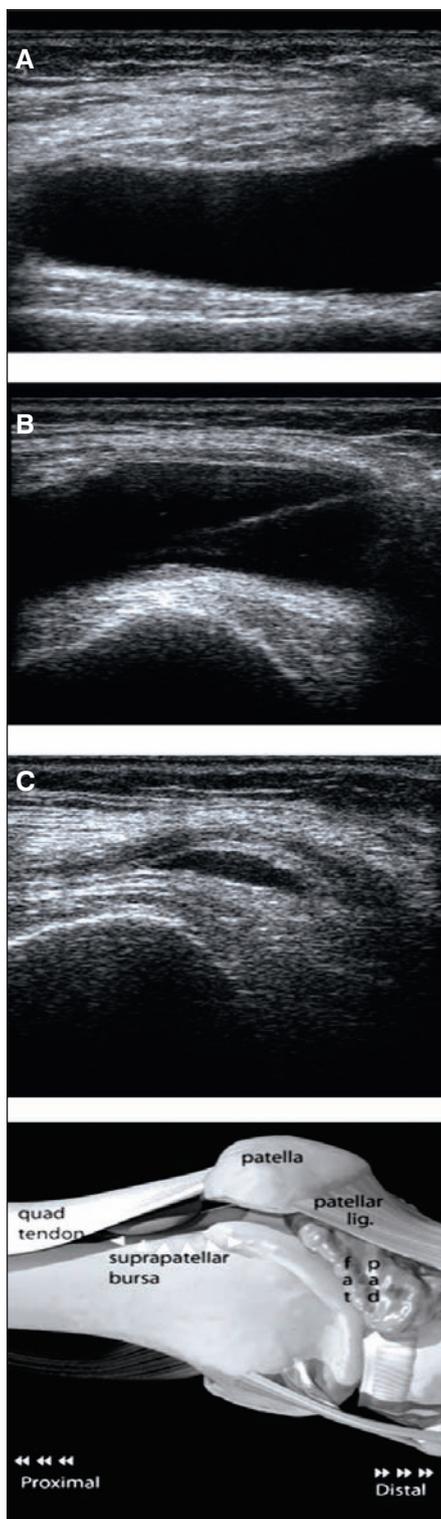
Suprapatellar aspiration.* A. longitudinal views of the suprapatellar pouch/bursa demonstrate a large anechoic fluid collection; B. needle insertion for aspiration; C. post aspiration view. Ultrasound image prior to aspiration allowed determination of no internal debris in the often recurring site of fluid accumulation.
